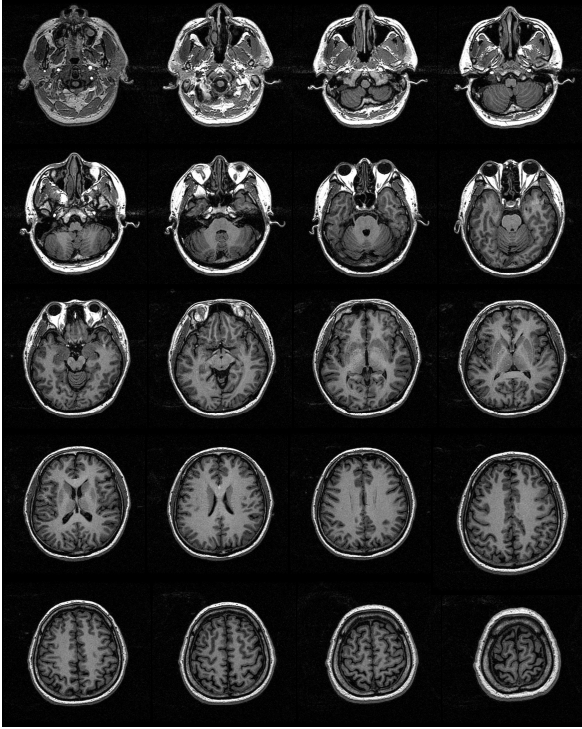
Some selected 2D slice of 3D T₁ MRI atlases of one brain
